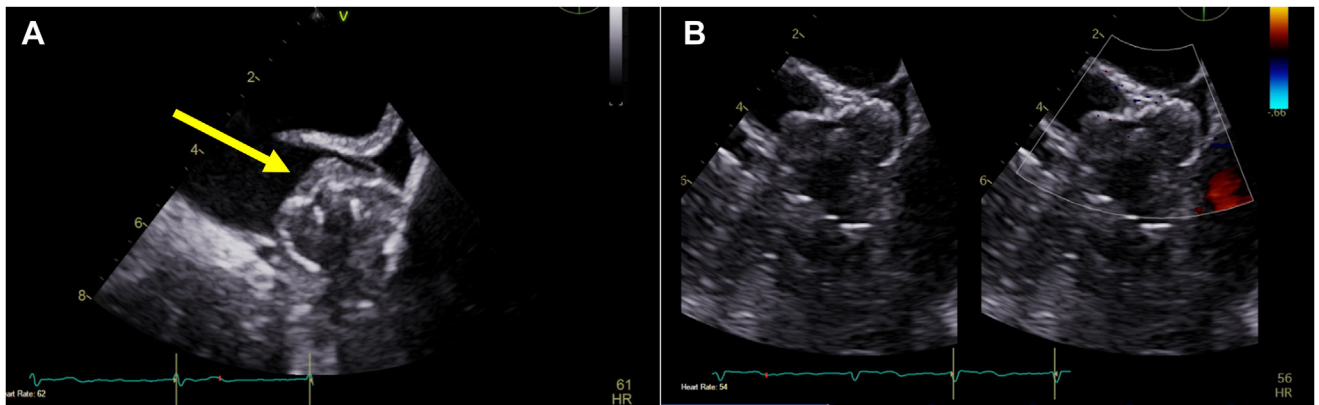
A: Transesophageal echocardiogram (TEE) at 90 degrees shows a laminar device-related thrombus (DRT) (yellow arrow). B: TEE showing the resolution of the laminar DRT.
